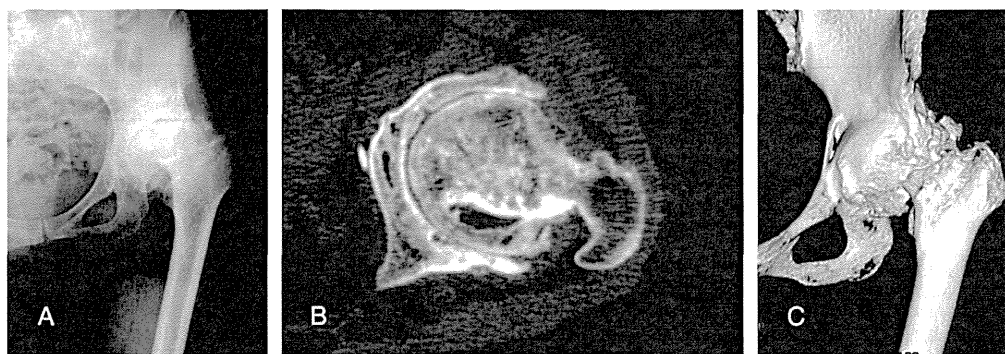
The preoperative left hip of a 63-year-old woman with osteoarthritis after rotational acetabular osteotomy. (A) Anteroposterior radiograph showing progressive osteoarthritis changes. (B) Axial computed tomography image showing a large osteophyte of the acetabulum needing removal, and the depth of the acetabulum. (C) Three-dimensional computed tomography image showing the three-dimensional shape of the acetabulum.
